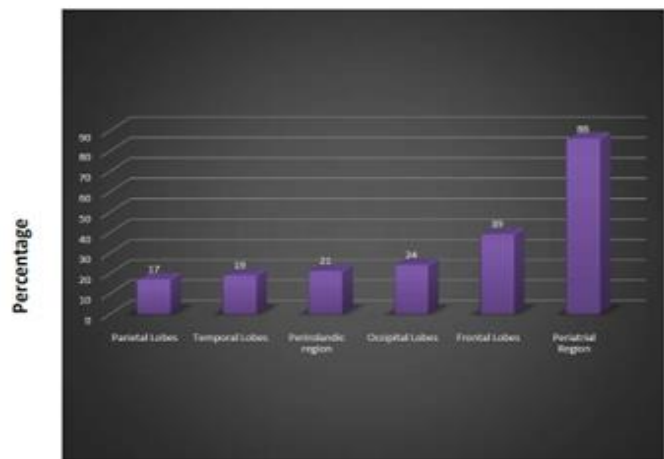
Distribution of study participants based on MRI findings.
